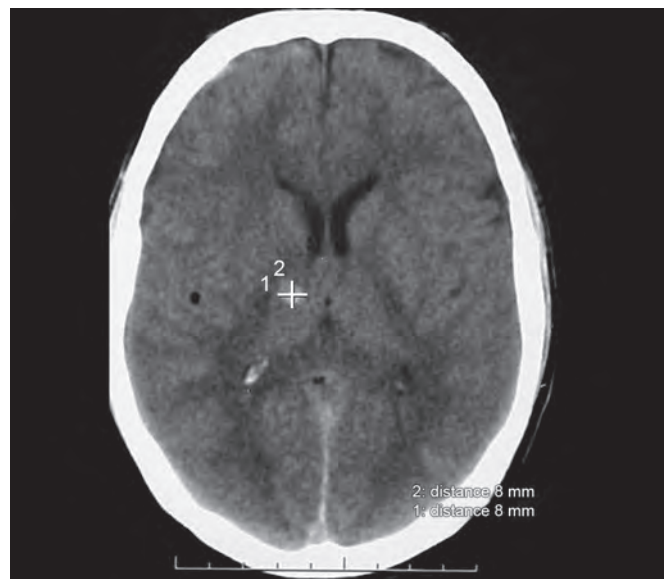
CT scan showing intermediate contusions
